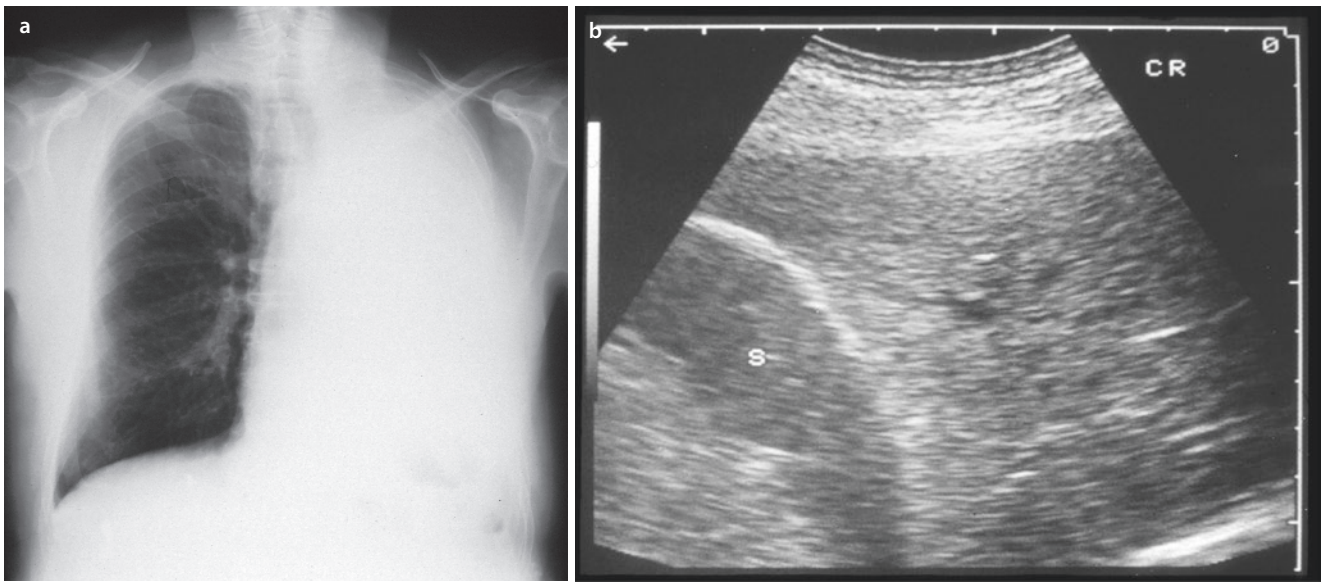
A 68-year-old man with a bronchial carcinoma. a Chest X-ray: homogenous shadowing of the left hemithorax. b Sonography: left-lateral intercostal echo transmission shows a complete hypoechoic
